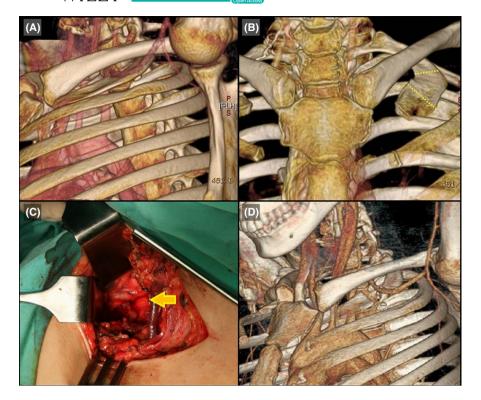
A, Preoperative three-dimensional computed tomography (CT) scan shows the first rib and the point that compresses the subclavian artery.
